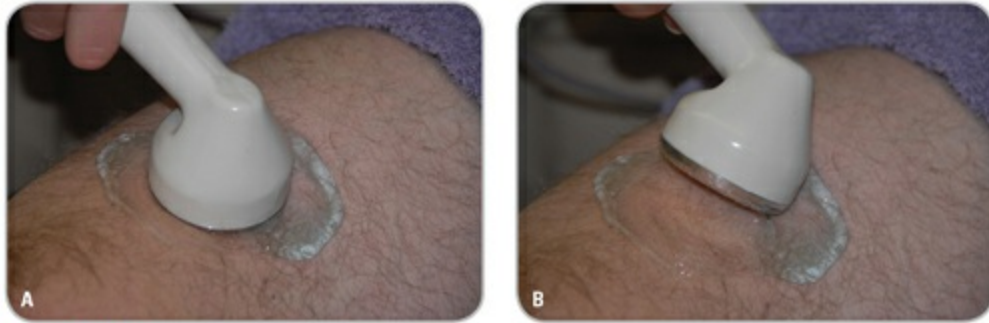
The cosine law. A, When energy is applied to a body part, the maximal effect occurs when energy rays strike the body at a right angle (90°). B, As the angle deviates from 90°, some of the energy is reflected away from the targeted site, thereby reducing the level of absorption. This concept is critical in the application of ultrasound.
